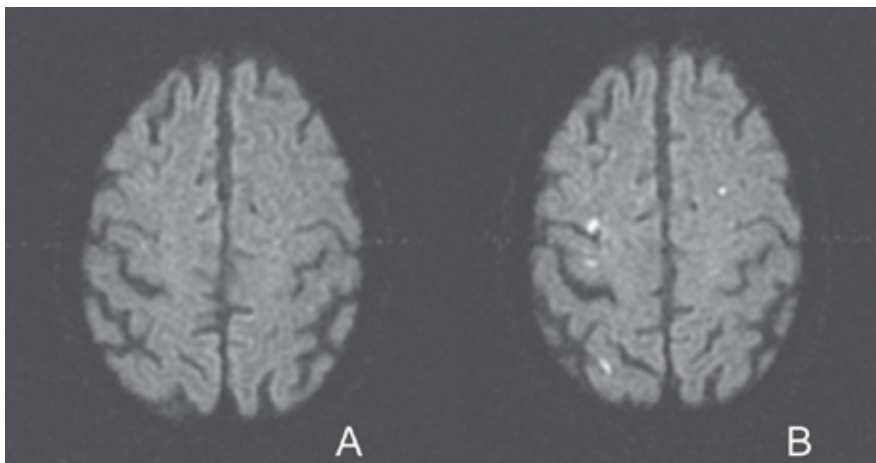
Patient number 9, 59 years old, underwent right CAS. DWI before CAS (A) without images of restriction. After CAS (B): ipsilateral NF (including primary motor rotation) and contralateral NF. Asymptomatic patient.
